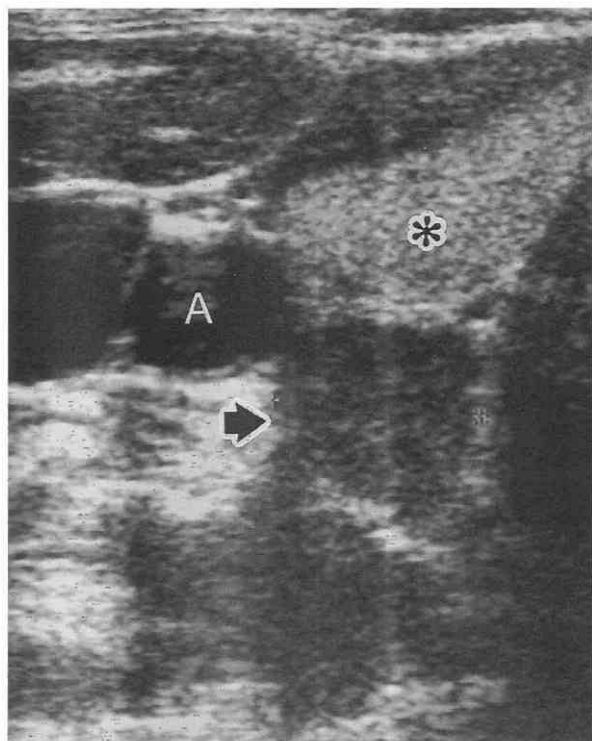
Parathyroid adenoma. Transverse sonographic image shows a hypoechoic mass (arrow) inferior to the right lobe of the thyroid (asterisk). A, right common carotid artery.
